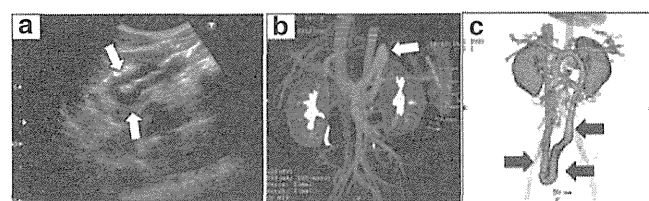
Ultrasonography and computed tomography (CT) portal venography of extrahepatic congenital portosystemic shunt patients. (a) Splenorenal shunt (arrow) was clearly visualized in the sagittal view on ultrasonography (16 y). (b) Splenorenal shunt (arrow) on maximum intensity projection image of CT portal venography (1.5 y). (c) Mesocaval shunt (arrow) on three-dimensional volume-rendered image of CT portal venography (5 y).
